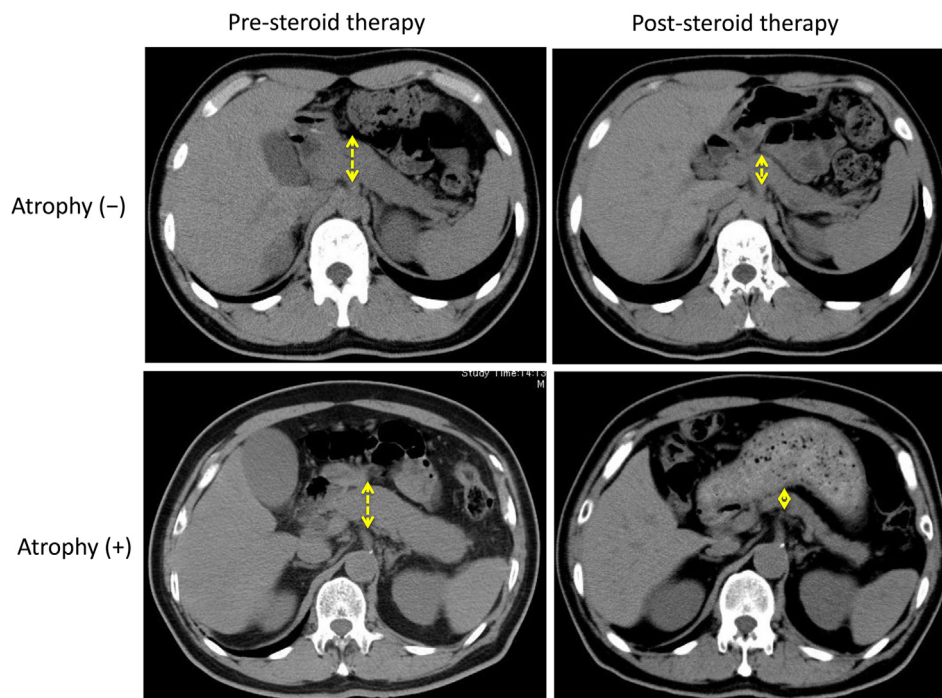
Typical image of the pancreas on CT with or without pancreatic atrophy after steroid therapy. Pancreatic atrophy after steroid therapy was defined to be present when the width of the pancreatic body was less than 10 mm.
